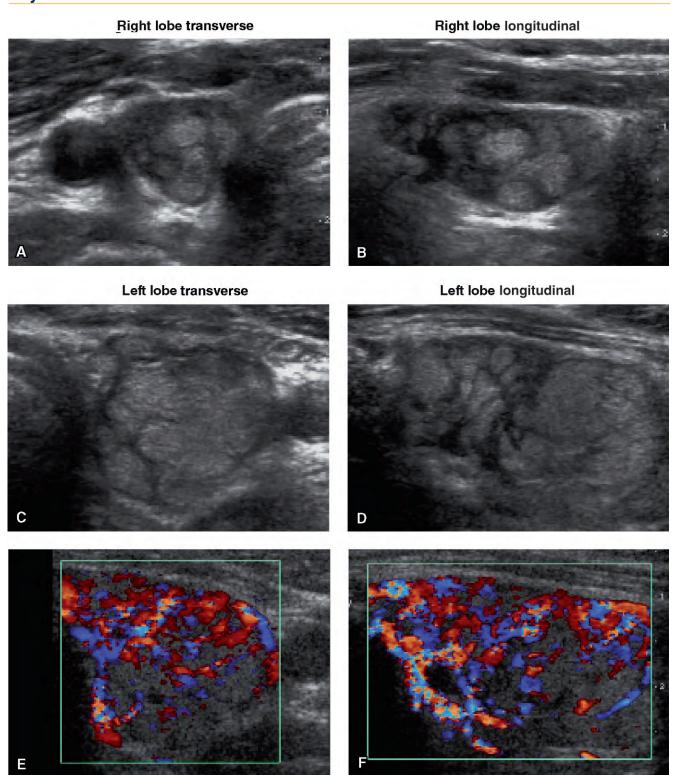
Ultrasound of thyroiditis in both lobes. A, Right lobe transverse. B, Right lobe longitudinal. C, Left lobe transverse. D, Left lobe longitudinal. E, Color Doppler, left lobe transverse. F, Color Doppler, left lobe longitudinal.
